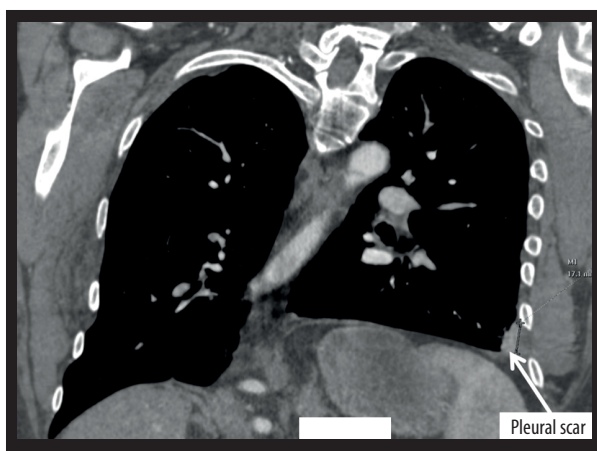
Pleural scar on the computed tomography scan 1 month after event.
